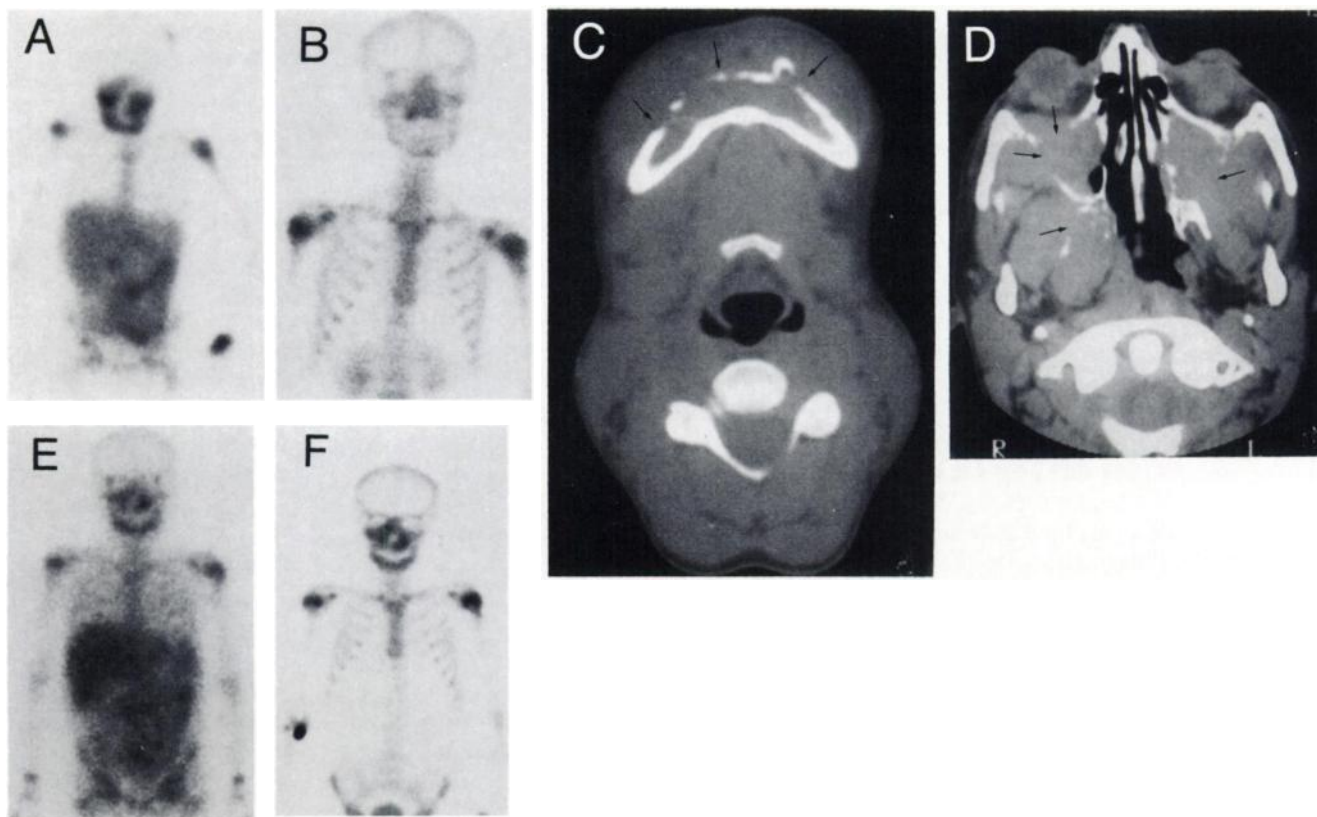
Gallium-67 and bone scintigraphy in a 10-yr-old male with Burkitt's lymphoma involving the bones of the face, the maxillary sinus and the left humerus. (A) Pretreatment ^{67}Ga scintigraphy shows involvement of the mandibles, maxillary bone and sinus, parietal bone and left humerus. (B) Bone scintigraphy shows the same lesions although less intense, particularly in the mandible. (C) Axial CT scan at the level of the mandible, shows a lytic lesion involving the anterior cortex. An extraosseous soft tissue mass (arrows) is also seen. (D) CT at the level of the maxillary sinuses shows a large mass in both sinuses destroying the right and left maxillary bones, and the right pterygoid apophysis (arrows). Note protrusion of the mass into the right orbit. (E) Gallium-67 scintigraphy during treatment showing marked reduction in uptake in all sites of disease. (F) Bone scintigraphy during treatment shows increased uptake, especially in the mandible, as compared to the pretreatment study.
